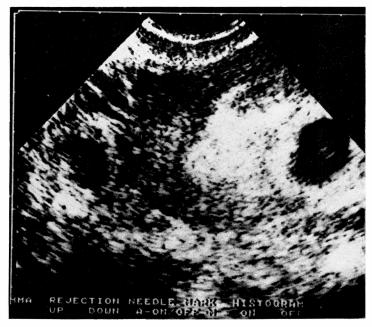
Transvaginal ultrasound of heterotopic pregnancy. Two gestational sacs are seen: (a) intrauterine with very thick endometrial appearance around the sac and (b) extrauterine on the left side.
